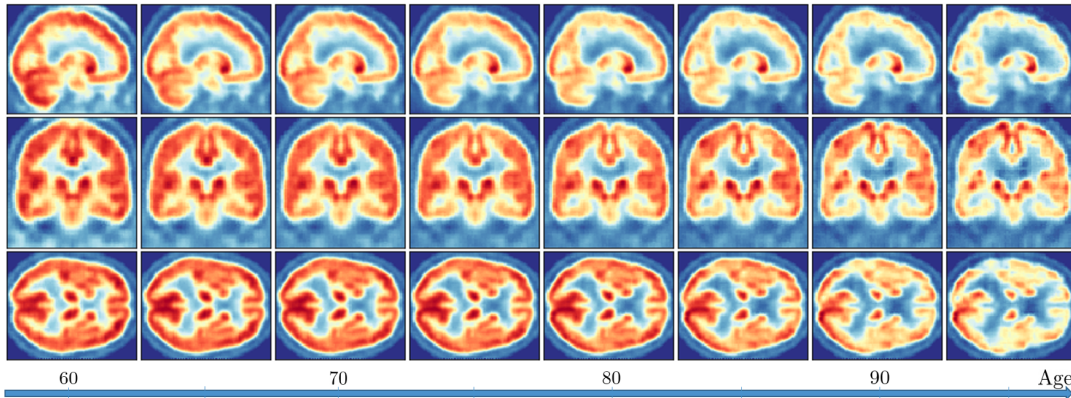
Sagittal, coronal and axial views of the average trajectory for FDG-PET scans, showing decreased level of metabolism across brain regions.
